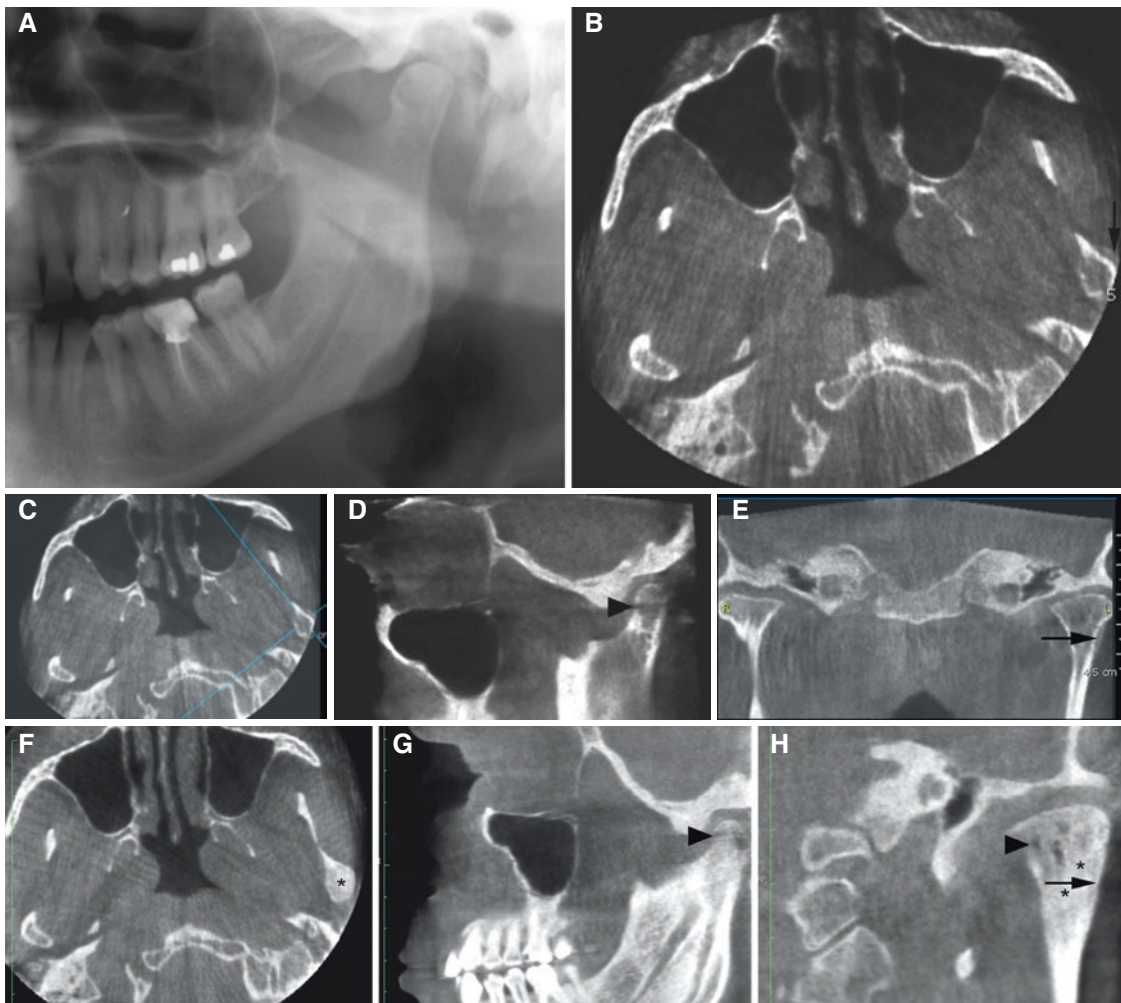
Prostatic cancer metastasis, temporomandibular joint; 57-year-old male with known disease and skeletal metastases. At baseline (A) Panoramic view shows dentition and jaw bone without pathologic findings. (B) Axial, (C) axial (with cursor lines), (D) oblique sagittal, and (E) coronal CBCT images show periosteal bone apposition of the left mandibular condyle (*arrow*) and bone destruction
